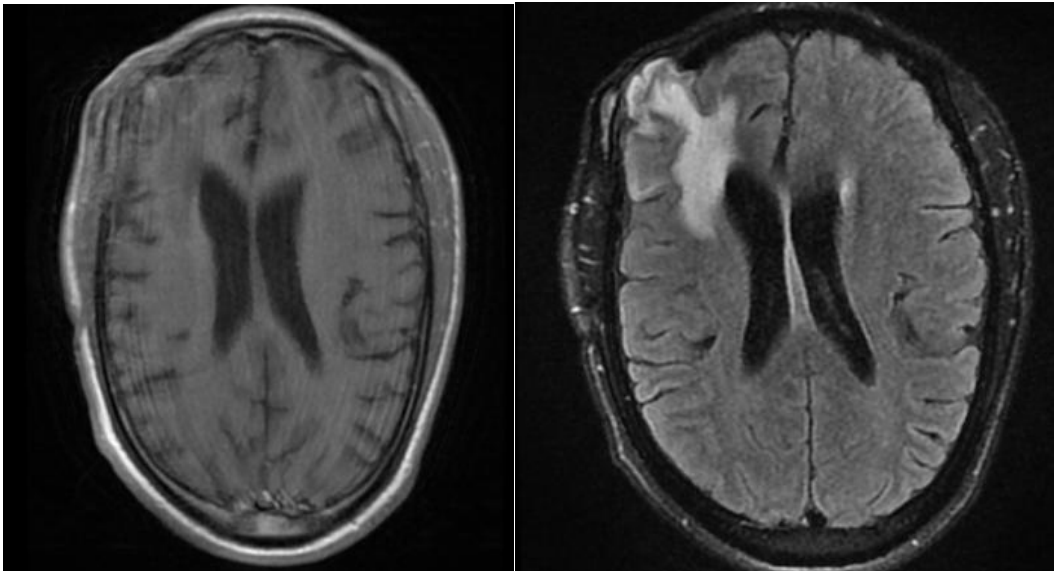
Post operative MRI T2 and T1 contrast.
